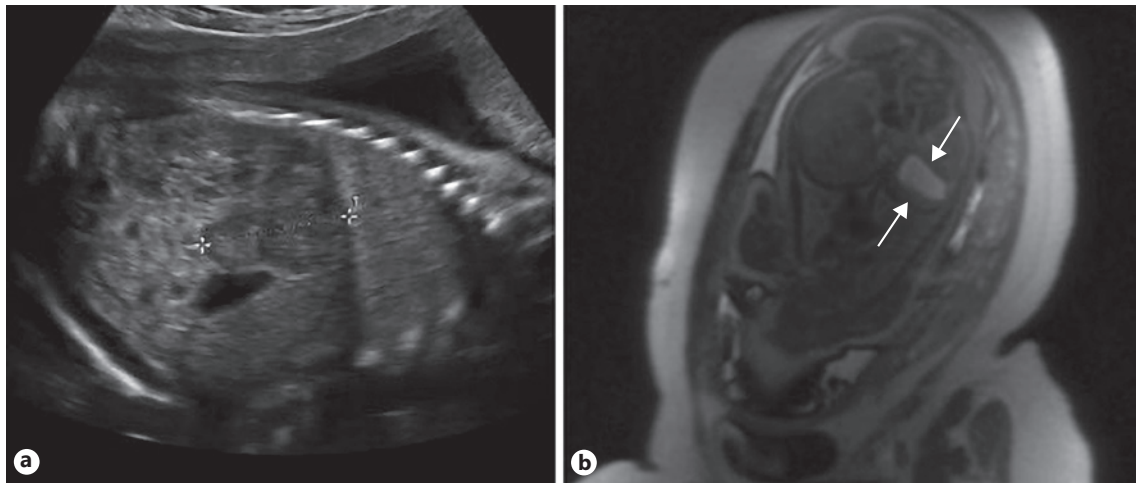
Adrenal hemorrhage. a Sagittal gray-scale ultrasound image of a heterogeneous mass in the left upper quadrant (calipers). b T1-weighted MRI of the fetus demonstrating a hyperintense left suprarenal lesion (arrows).
